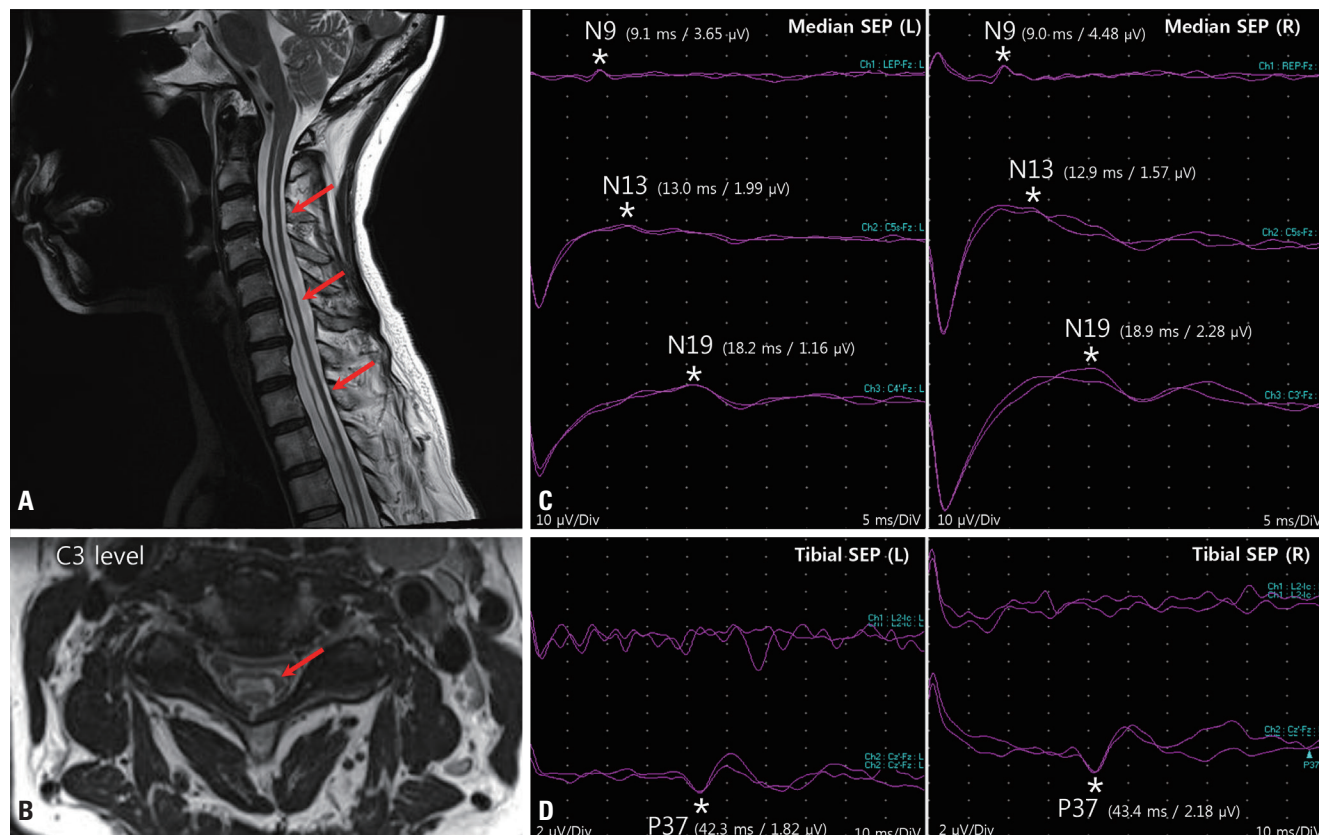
Sagittal (A) and axial (B, C3 level) images from cervical spine T2-weighted magnetic resonance imaging. An extensive syrinx had developed within the spinal cord (from C2 to T10) (arrows). Median somatosensory evoked potentials (SEPs) (C) were normal for N9 but small for N13 and N19. The tibial SEP (D) was normal for P37 bilaterally in the lower limbs. *Represent the locations of each potential.
